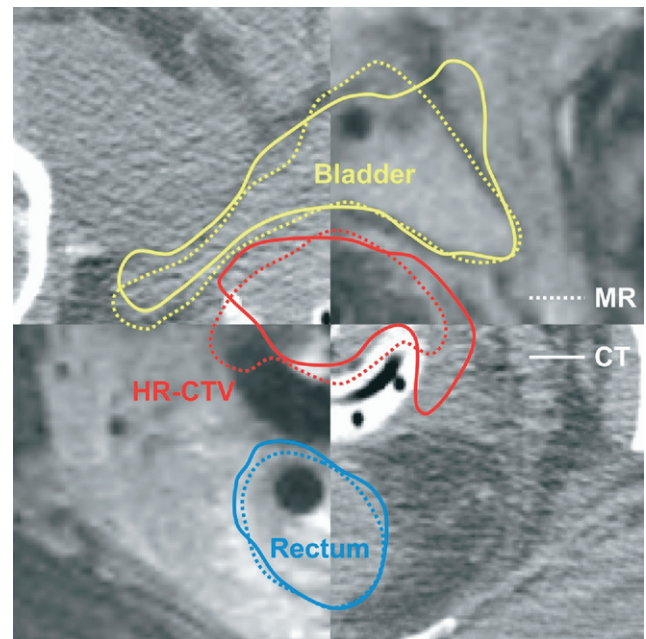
Example of fusion between axial computed tomography (solid line) and magnetic resonance imaging (dotted line) scans with contours for rectum, bladder, and high-risk clinical target volume in patient with tandem and ring brachytherapy applicator inserted into cervix. Outer rectum contours overlap nicely; bladder contours show only slight deviations. The high-risk clinical target volume contour highlights the difference in lateral extension seen between computed tomography and magnetic resonance imaging and reveals difficulty in accurately assessing the lateral dimension.
